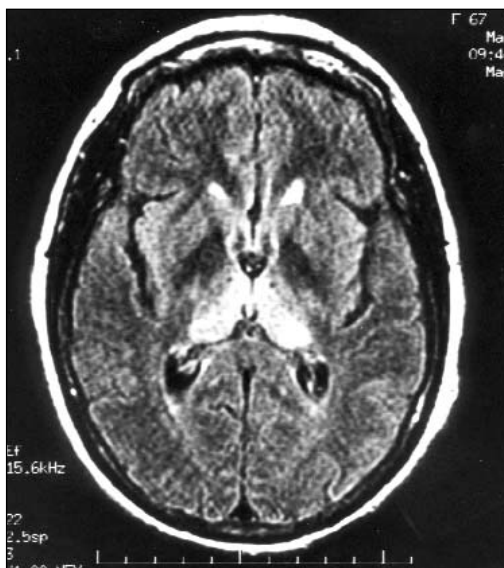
MRI head axial FLAIR image shows symmetric signal hyperintensity in the thalami bilaterally, most marked posteriorly. There is also subtle signal hyperintensity in the corpus striatum.
